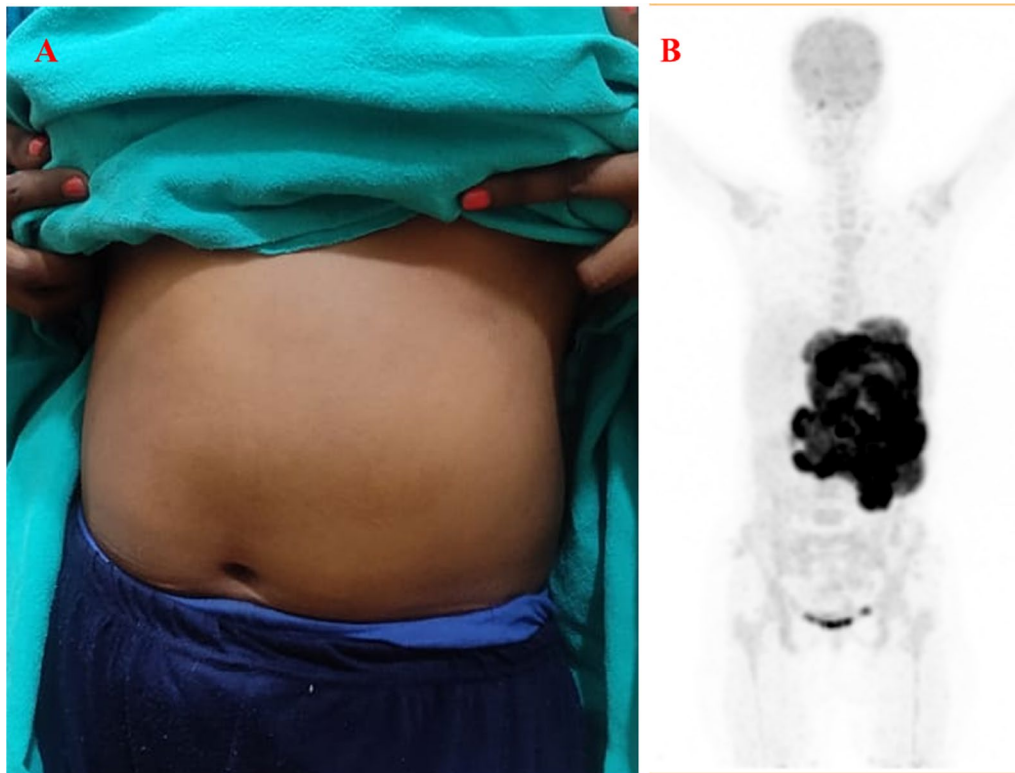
A 20-year-old female, presented with left sided abdominal distention (A) and upper abdominal pain for 8 weeks. Maximum intensity projection (MIP) image of 18F FDG PET scan shows a large area of tracer uptake in the left side of the abdomen (B)
